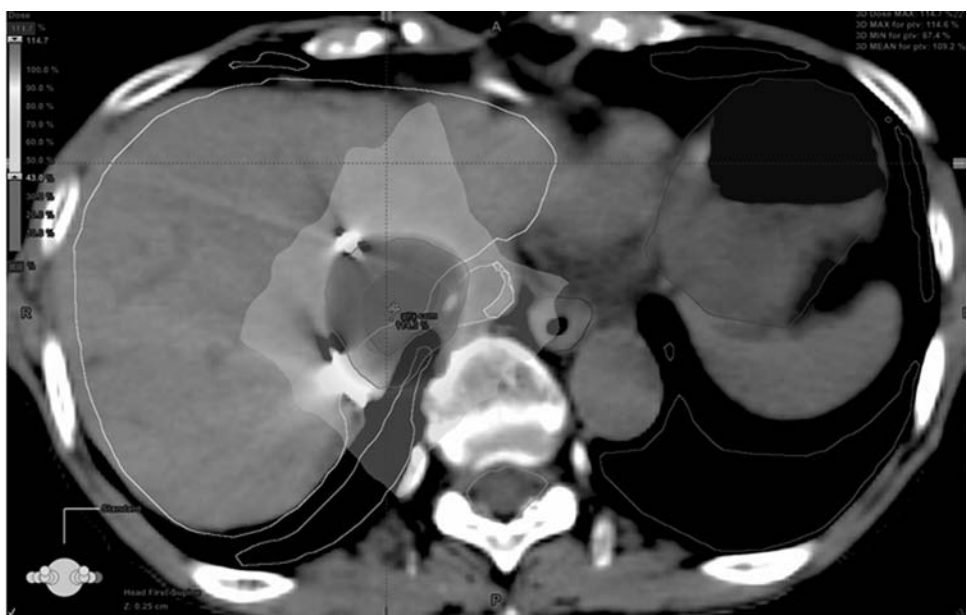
An axial CT image demonstrating the conformal SBRT isodose color washes around a liver metastasis in a patient with oligometastatic colorectal cancer with markers placed for four-dimensional treatment planning and delivery.
